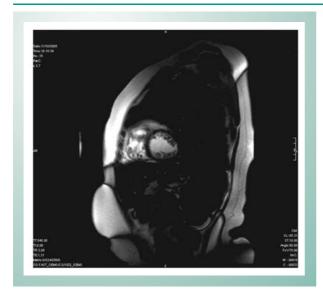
Magnetic resonance imaging: increased myocardial trabeculations.
